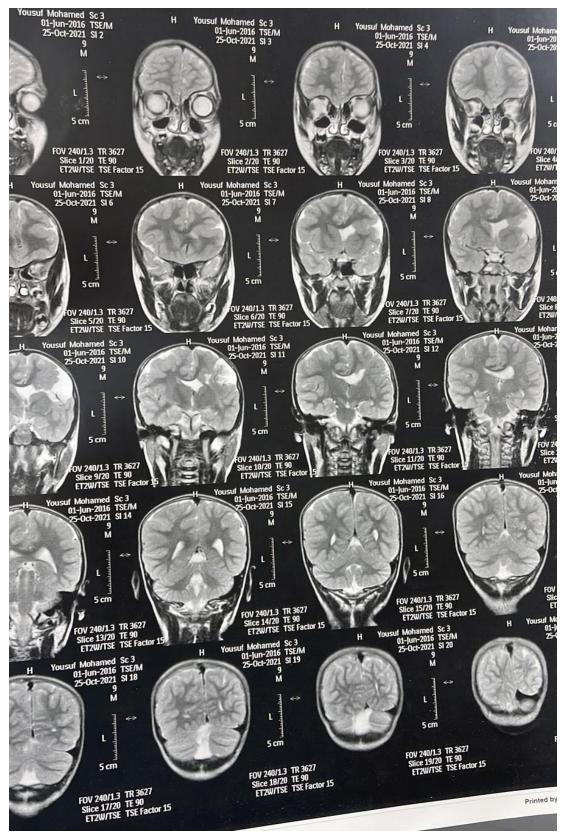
MRI showing open lip schizencephally (left tempro-parital cleft and absent septum pellucidum.
